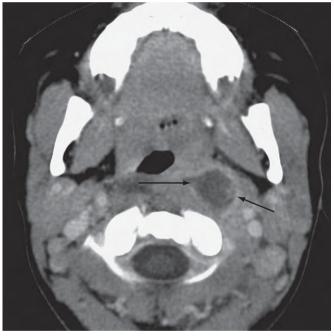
Retropharyngeal abscess: 3-year-old boy with fever and a stiff neck. Lateral radiograph (A) demonstrates thickening of the prevertebral soft tissues (*white arrows*). On a contrast-enhanced CT image (B), there is a rim-enhancing well-circumscribed low-attenuation lesion in the left retropharyngeal space (*black arrows*) consistent with an abscess.
